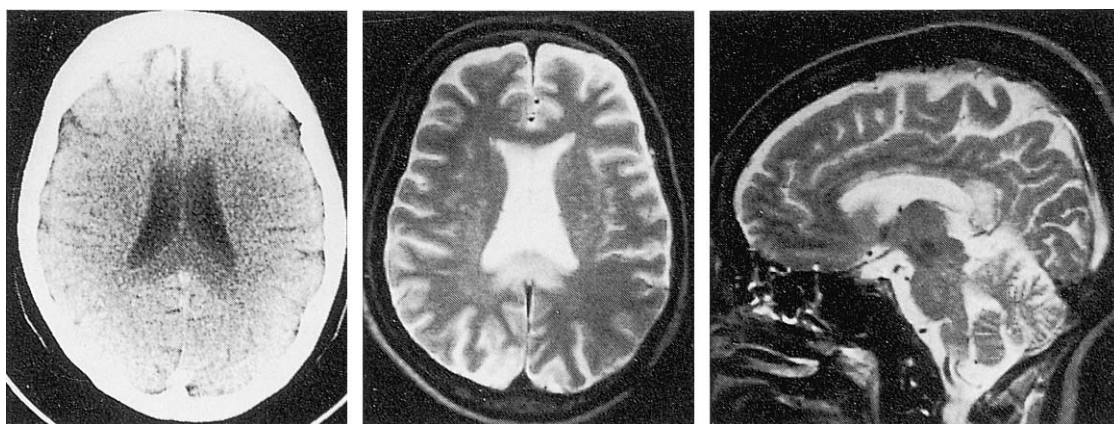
CT and MR images on admission. CT disclosed abnormal hypodensity of the splenium. Axial and sagittal T2-weighted MR images (SE 2500/90/1) revealed abnormally high signal intensity in the splenium, in the central zone of the trunci of the corpus callosum and in the deep white matter. Swelling of the splenium was also noted.
